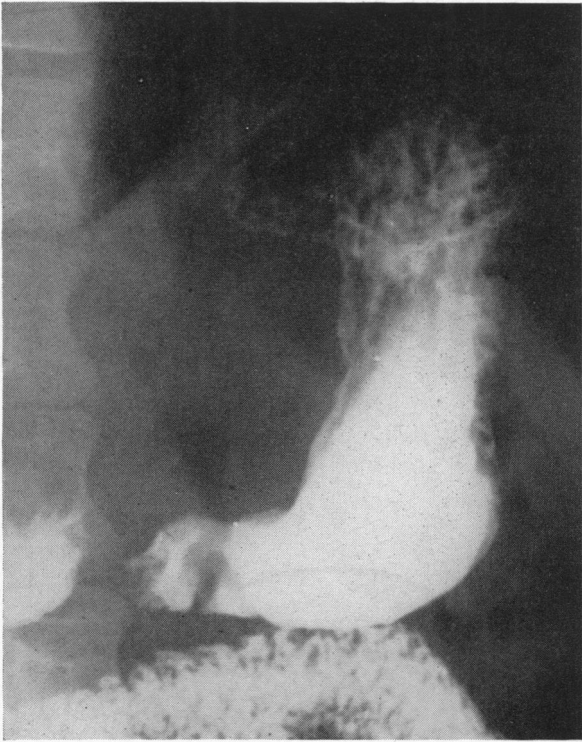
Roentgenogram of 56-year-old man with history of ulcer for two years. Films were read as showing a prepyloric ulcer. Medical treatment prescribed. 1941.
